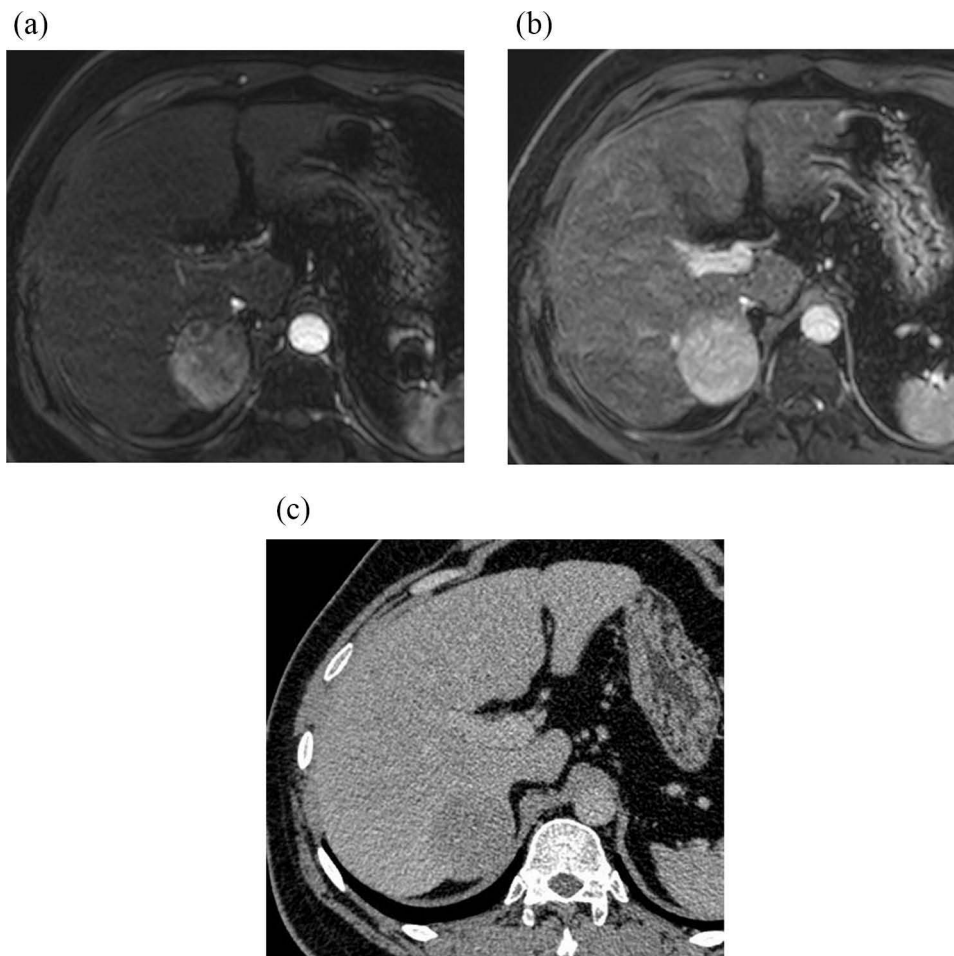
56-year-old man with cirrhosis and HCC. (a) APHE of Gd-EOB-DTPA MRI. Figure (b) shows no washout and no capsule in PVP of Gd-EOB-DTPA MRI. Tumor diameter > 2cm, and LR-4. Figure (c) shows washout in delayed phase of CT. Adding CT delayed phase images to Gd-EOB-DTPA MRI, the lesion was classified as LR-5.
